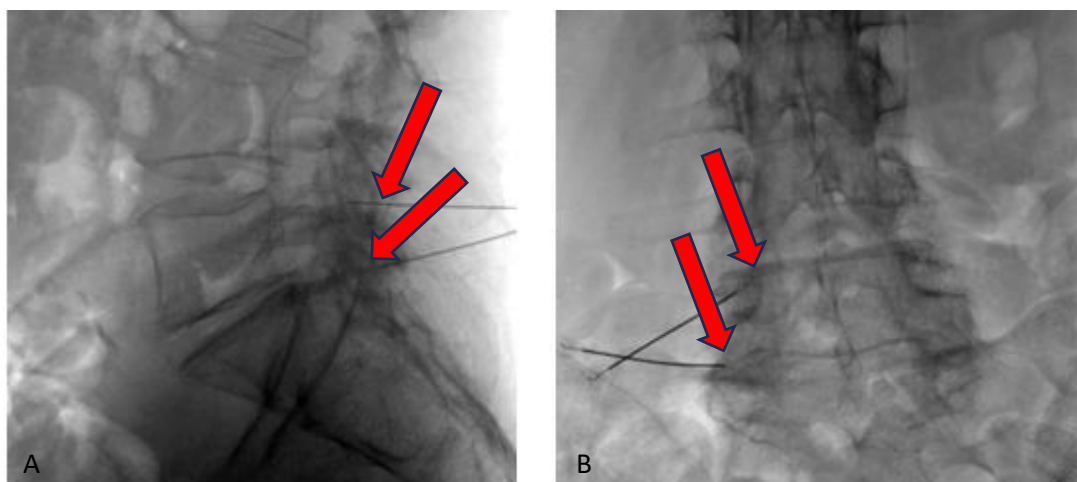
LL X-ray (A) and AP X-ray (B): assessment of proper needle positioning for treatment of the facet joints (arrows).
